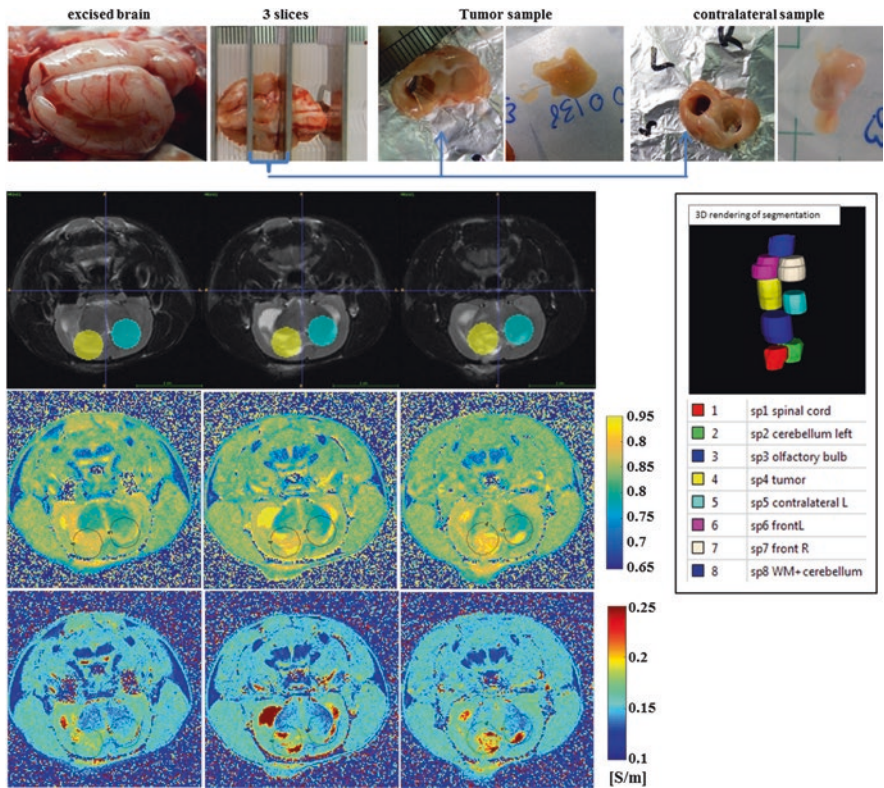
Experimental procedures in F98 tumor-bearing rat5 for the final in vivo MRI images, which were acquired 14 days post-injection of tumor cells. (top) The excised brain was cut into three slices, the middle one containing the tumor and contralateral samples. The three slices corresponding to the middle brain slice containing the tumor (id = 4, yellow) and contralateral sample (id = 5, cyan). These three slices are reproduced in the T2w image with the overlaid segmentation (middle). A 3D rendering with the label description is provided to the right. (bottom) Corresponding WC and $\sigma^{200\text{kHz}}$ maps are presented. Outlines of the segmentation are superimposed on these maps
